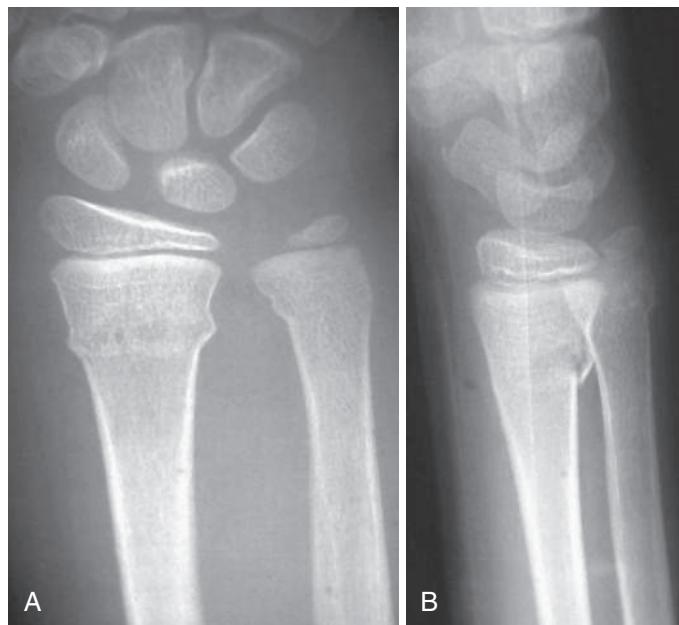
Buckle fracture is a partial failure in compression. Anteroposterior (A) and lateral (B) radiographs of the distal radius. (From Dormans JP. Pediatric Orthopedics: Introduction to Trauma. Philadelphia: Mosby; 2005:37.)
